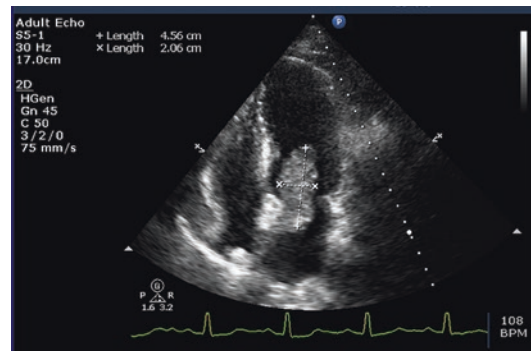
A 2D transthoracic echocardiography image of left atrial myxoma crossing the mitral valve during diastole
